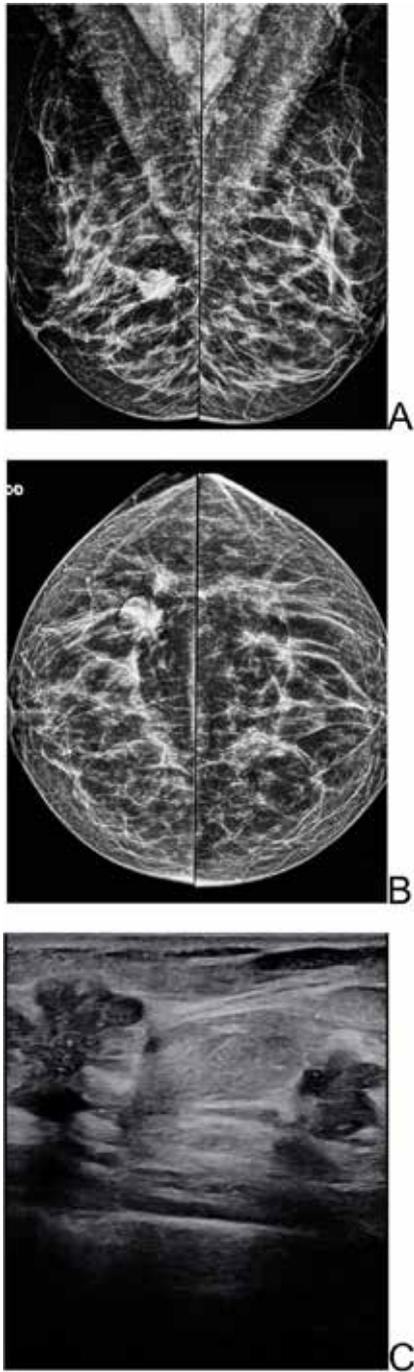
A and B. Mammography, MLO and CC views showing two tumors in the right LOQ breast, with irregular shapes, spiculated margins and hyperdense. C. Ultrasonography showing two tumors in the LOQ of the right breast, with irregular shapes, spiculated margins, indistinct, angular, hypoechoic and non-parallel orientation.
